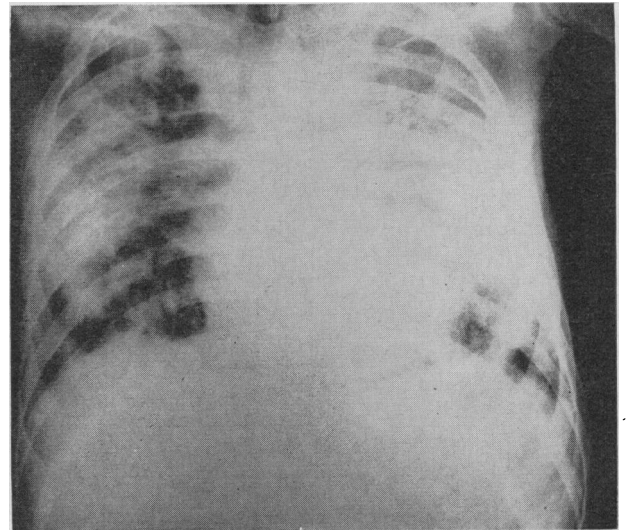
Chest radiograph of recipient two weeks before transplantation (September 1965).
